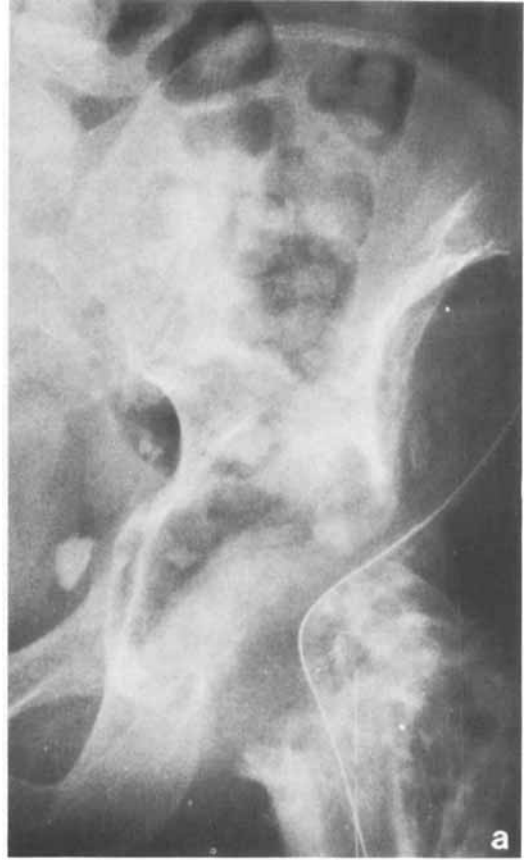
(Case 5). a. Left hip radiograph showing extensive post-infective destructive changes involving the acetabular fossa and femoral head. b. CT scan at the acetabular level delineates the extent of destruction of the medial acetabular wall, anterior acetabular rim and femur.
